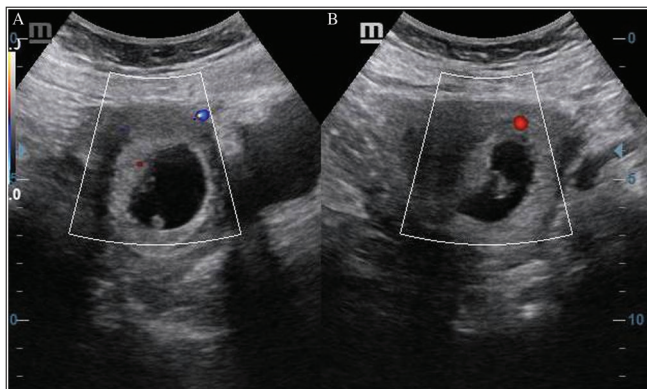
Transverse view of ultrasound examination of gestational sac showed chorionic villi on right superiolateral side of sac. (B) At longitudinal view showed posterior chorionic villi
